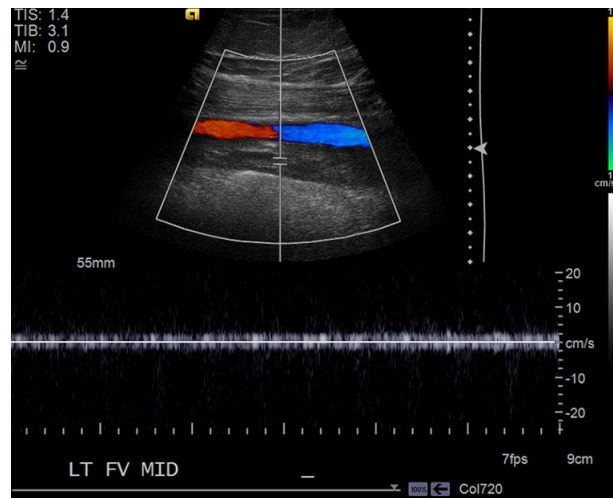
Venous color flow Doppler. Doppler ultrasound imaging of the left femoral vein showed complete occlusion by heterogeneous thrombus with dilated veins at the site of thrombosis.
